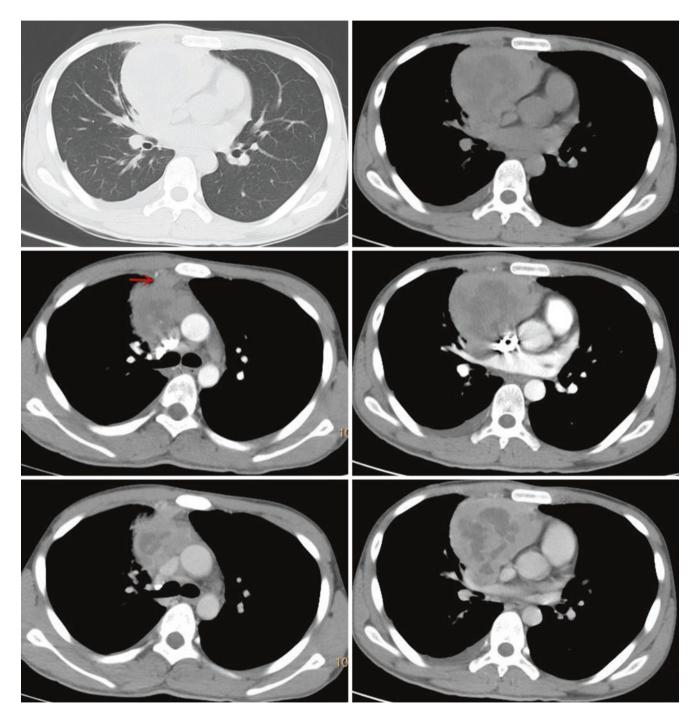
Chest CT images of a 16-year-old man complained of chest pain for 1 month
